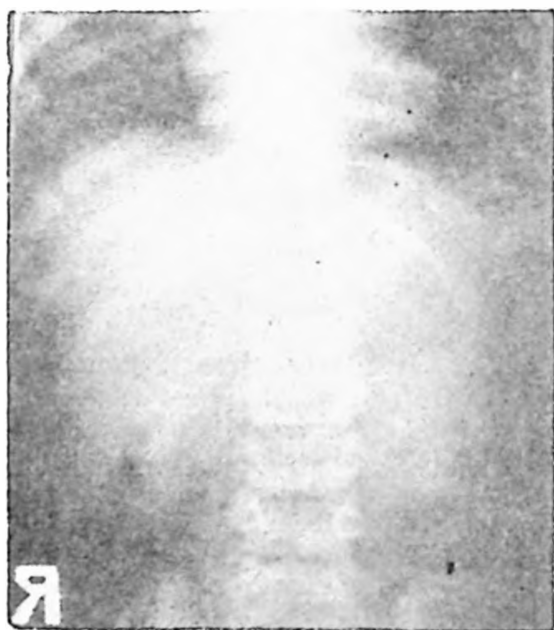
Anteroposterior direct x-ray examination of the vertebral column in case 4.
